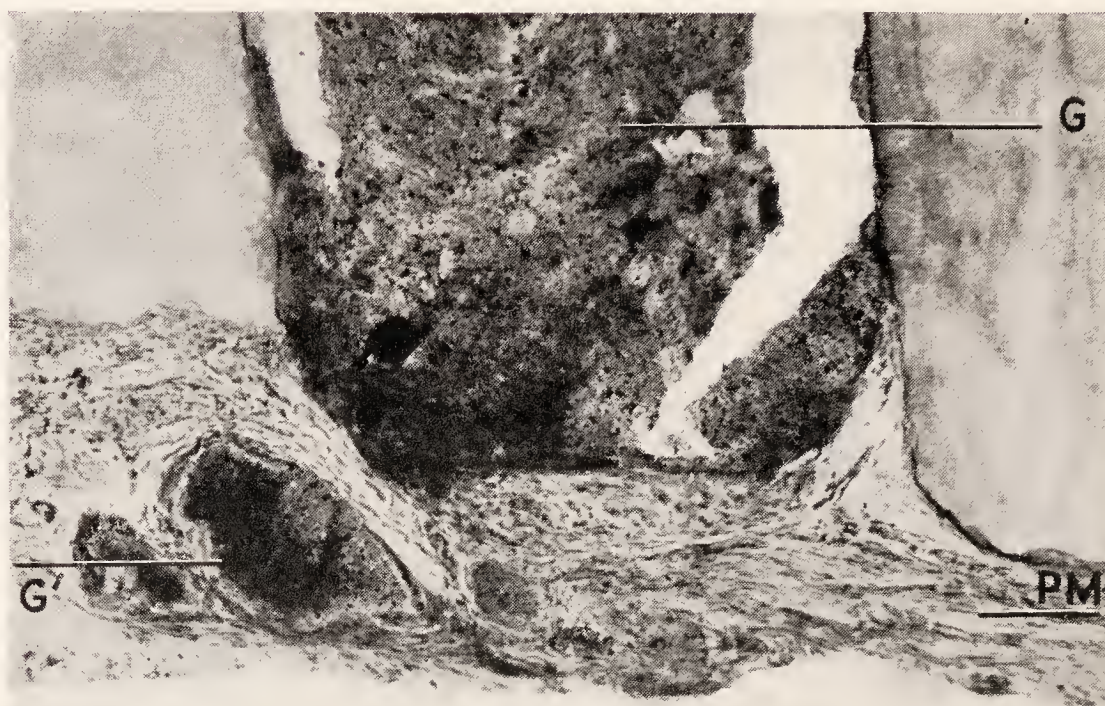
Root end of lower cuspid. Chronic periapical infection treated and root canal filled nine years before extraction. G, guttapercha in root canal; G', particles of guttapercha dislodged beyond the apical foramen; PM, periodontal membrane. (Courtesy of E. D. Coolidge.)
